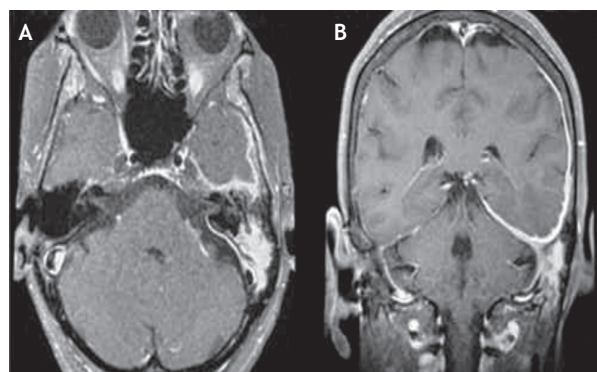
A, Axial view of head magnetic resonance imaging shows the high T2 signal in left mastoid cells. B, Coronal view of head magnetic resonance imaging exhibits ipsilateral cerebellar tentorium and middle fossa leptomeningeal plan enhancement after gadolinium is injected.
